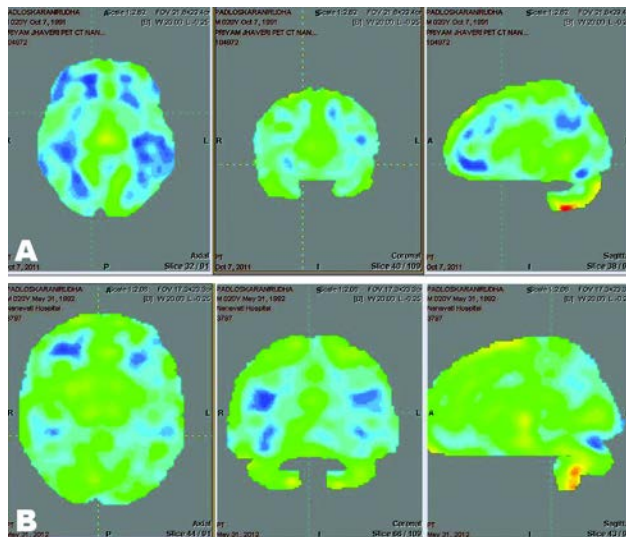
(A) Pre Stem cell therapy PET CT scan showing blue areas with hypometabolism (B) Post Stem cell therapy PET CT scan showing decrease in blue areas which is replaced by green areas indicating improved functioning of the brain
